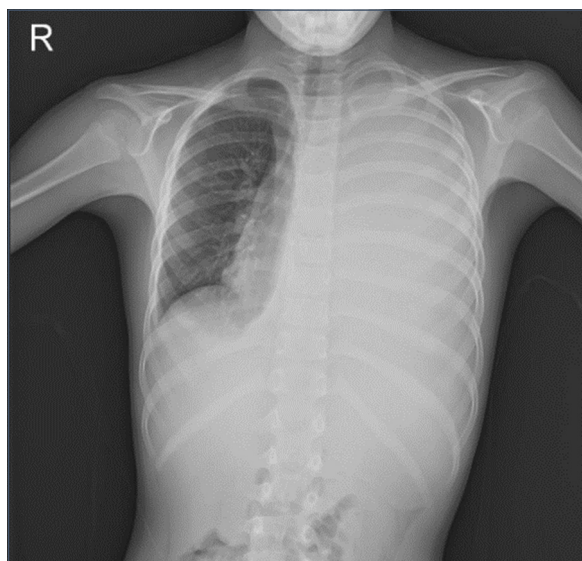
Chest X-ray performed at the second consultation, showing massive left pleural effusion with mediastinal shift.
